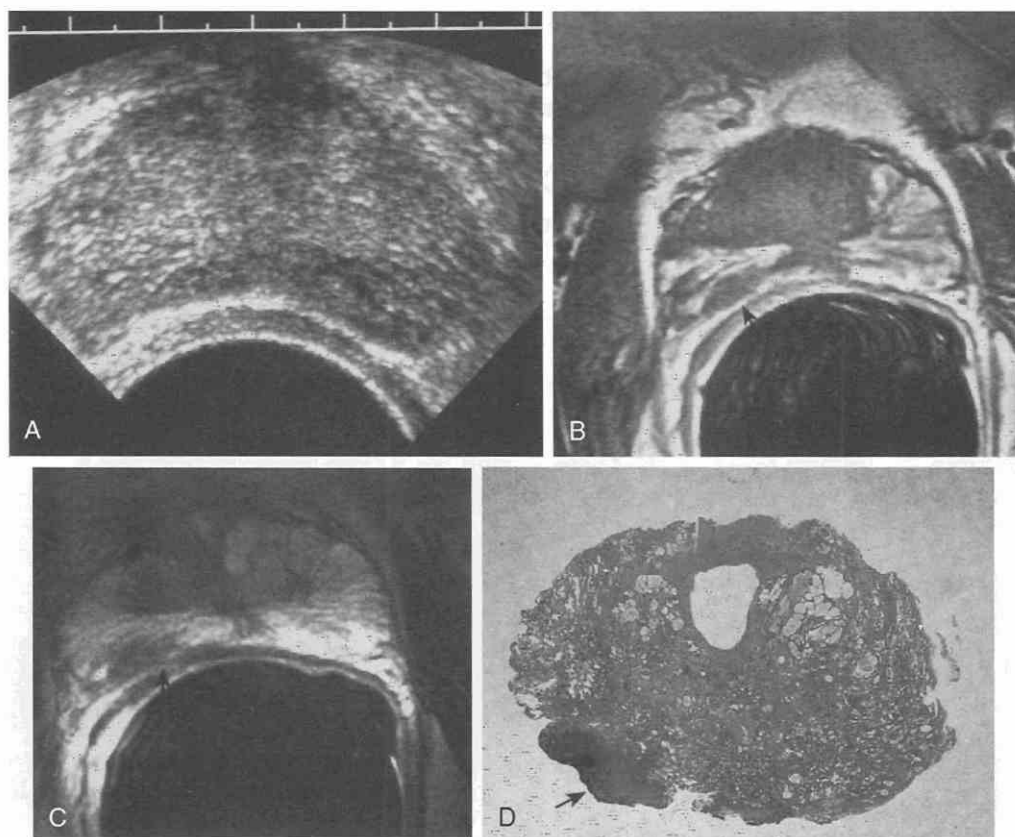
Peripheral zone prostate carcinoma. A, Transrectal ultrasonography shows a left-sided area of hypoechogenicity in the peripheral zone, the site of suspected carcinoma in this patient. Biopsy findings of the left side were negative, whereas biopsy results of the right peripheral zone were positive. B, Axial T1-weighted, endorectal coil image shows hemorrhage throughout the peripheral zone of the prostate. Hemorrhage does not enter a small focus in the right posterior peripheral zone (arrow). C, T2-weighted, fast spin-echo image shows low signal intensity in the right peripheral zone (arrow), indicating the site of the tumor. Signal intensity is similar to that in the central gland. D, Whole-mount section of the prostate shows the right-sided cancer (arrow) in the peripheral zone.
